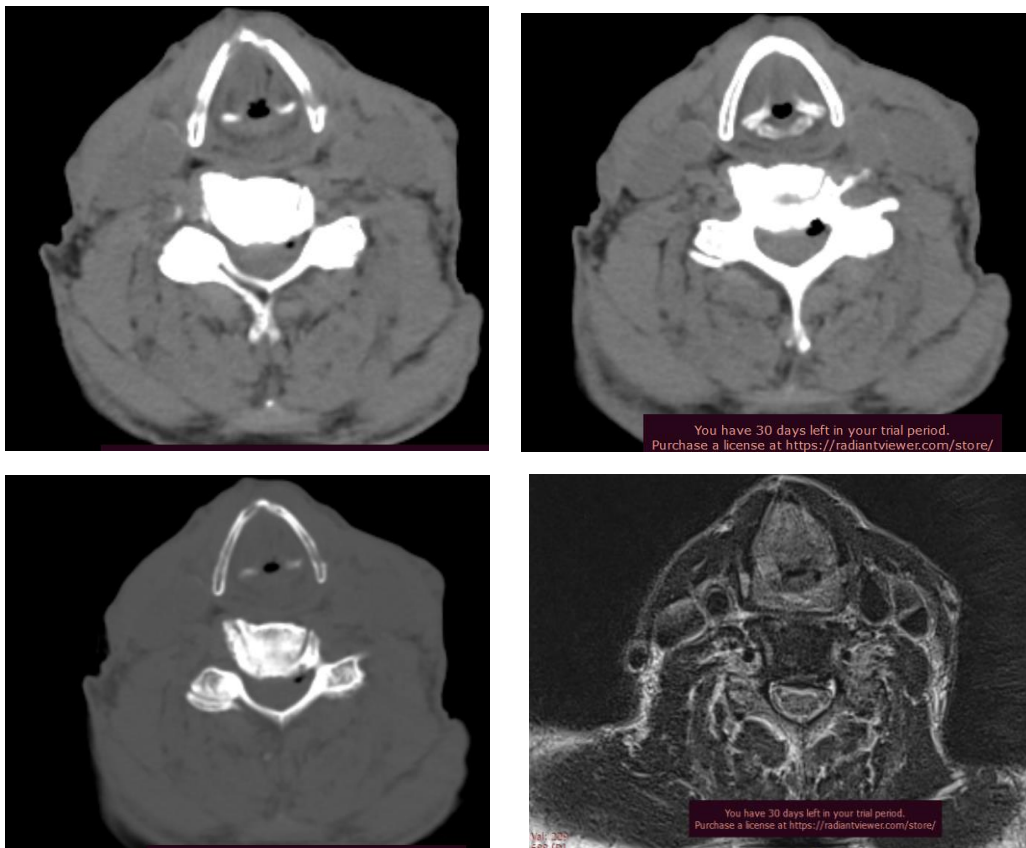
A, B,C and D : axial non contrast CT scan of the neck soft tissue and bone windows images at the level of the true vocal cords (A,B and C) are showing a well defined soft tissue mass lesion seen centered over the right vocal cord extending to the anterior commissure and subglottic region without cartilage invasion D: Axial BLADE T2WIs MR Image of the same patient at the corresponding level to the CT images revealing a hyperintense signal mass with anterior fissural extension. No extra laryngeal spread.
